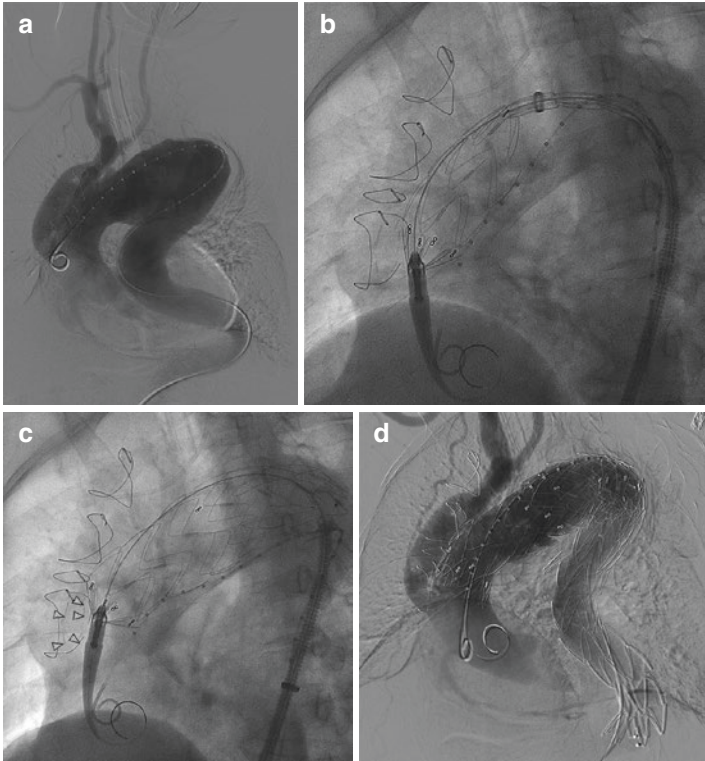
(a) Aortography showing aortic arch aneurysm and supra-aortic branch bypass with good flow. (b) Chest X-ray of the endovascular procedure showing the deployment of the ascending aortic endoprosthesis with a closed free-flow tip (in order to avoid graft migration) just after the metallic clips (indicated by arrows' head in c) sutured around the ascending aortic graft. (c) Chest X-ray of the endovascular procedure showing the deployment of the ascending aortic endoprosthesis with a closed free-flow tip (in order to avoid graft migration) just after the metallic clips (indicated by arrows' head in the figure) sutured around the ascending aortic graft. (d) Final aspect of the endovascular procedure with contrast showing no endoleaks and good flow of the bifurcated graft
